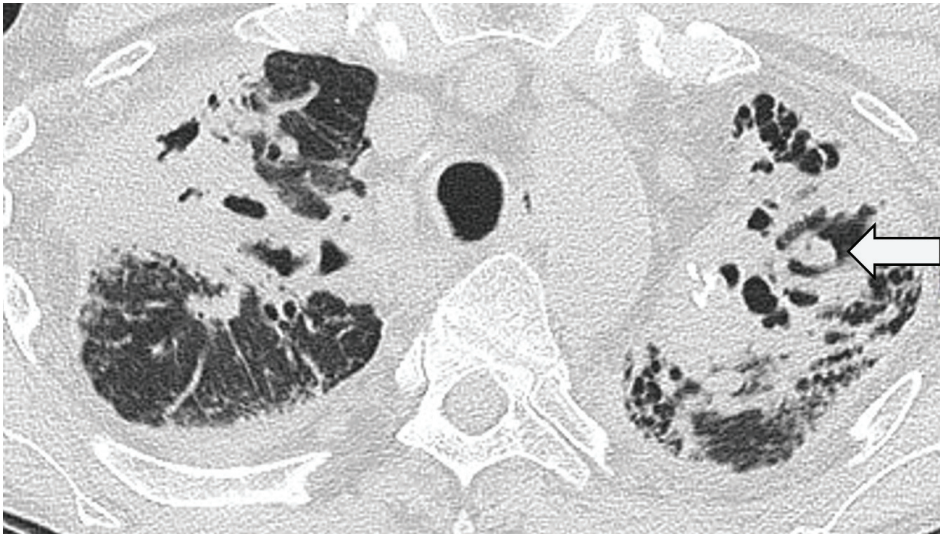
CT through the upper zones in a 61-year-old patient with pulmonary sarcoidosis. There is extensive disease with bronchocentric fibrosis manifest as a pattern of the consolidated lung. Note that in the left upper lobe, there is evidence of cavitation with a small aspergilloma (arrow).
